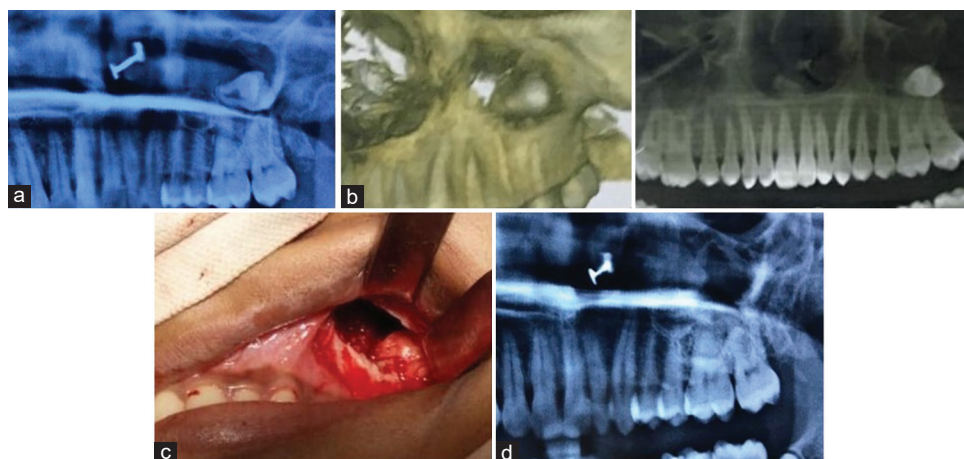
Radiographic and clinical images for dentigerous cyst in association with maxillary third molar; (a) Preoperative radiograph, (b) CBCT images of Maxilla, (c) Intraoperative maxillary sinus showing third molar, (d) Postoperative radiograph
